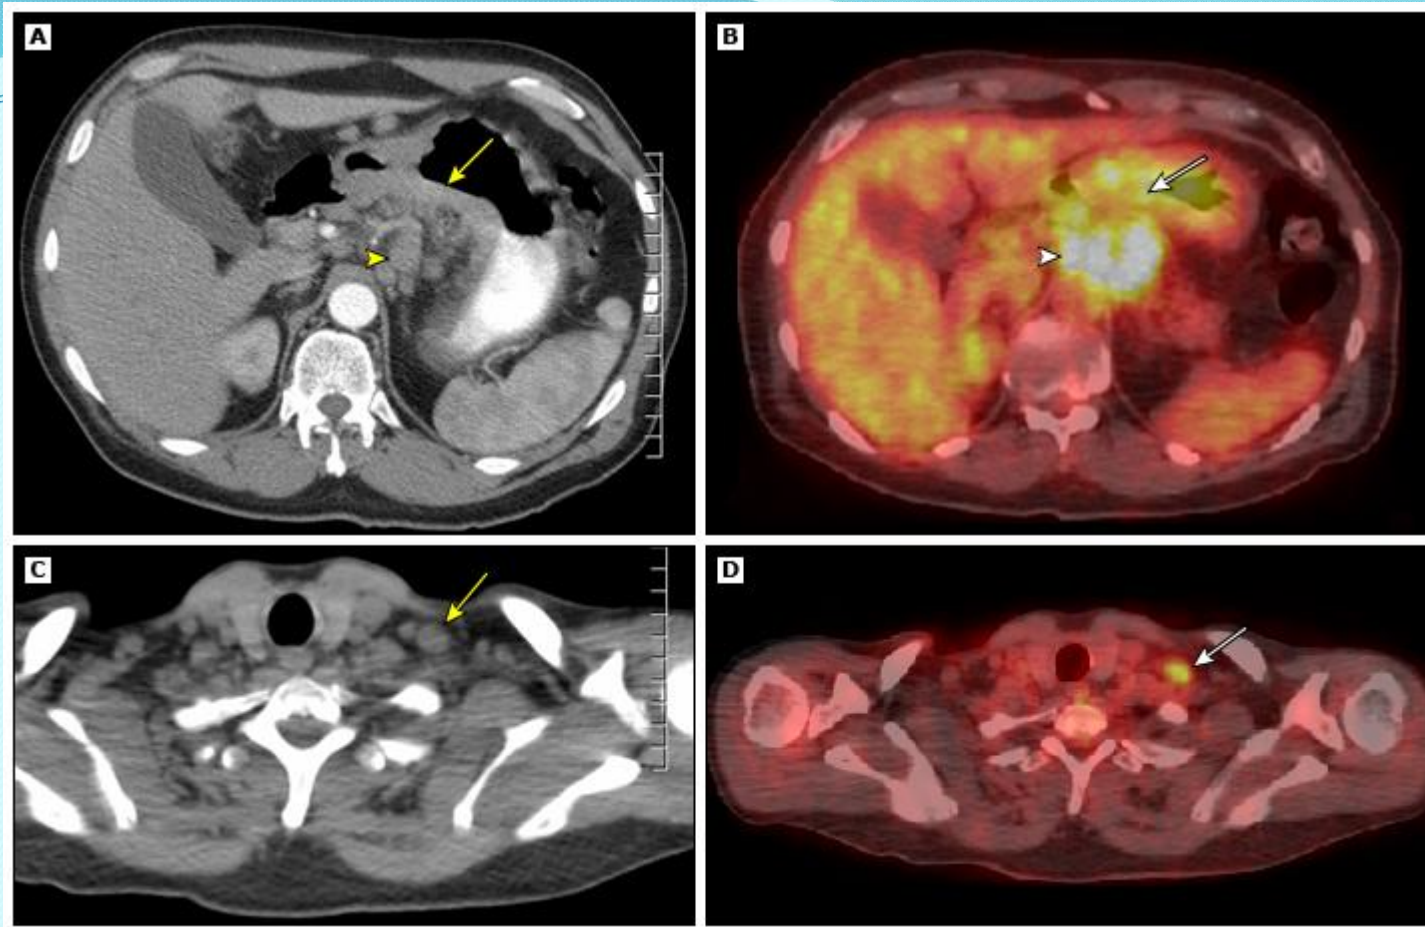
A CT scan of the abdomen showing a gastric cancer arising in the body of the stomach.
